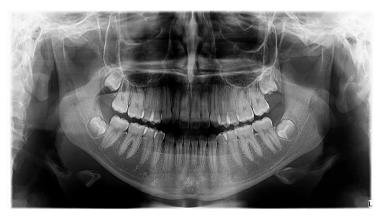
Panoramic X-ray before orthodontic treatment
